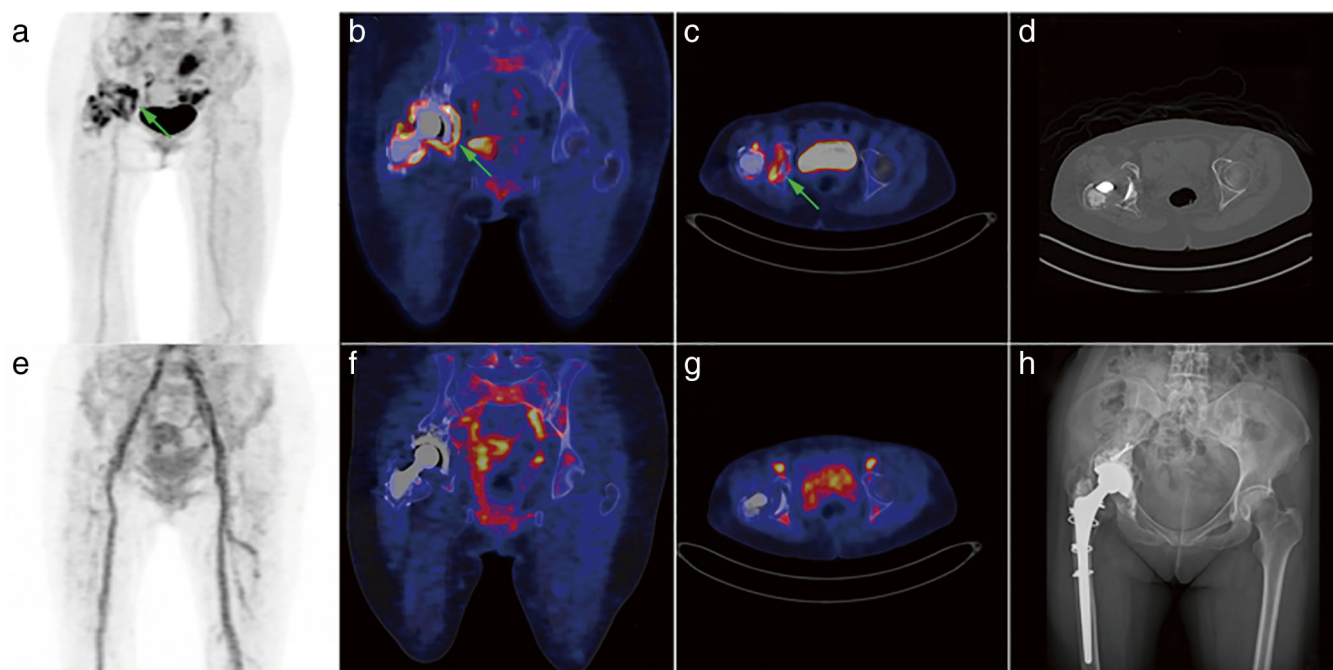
Imaging findings of [^{18}F]FDG PET/CT and [^{68}Ga]citrate PET/CT in a patient with a history of right total hip arthroplasty performed 16 years prior to imaging. [^{18}F]FDG PET/CT showed increased uptake around the prosthesis (a–d, green arrows), while [^{68}Ga]citrate PET/CT had no obvious tracer uptake (e–g). Cup loosening with synovial hypertrophy and clear joint fluid were observed during surgery. This confirmed [^{18}F]FDG PET/CT false positives. Adapted from Tseng *et al.* [34] (this article is distributed under the terms of the creative commons attribution 4.0 international license: <http://creativecommons.org/licenses/by/4.0/>).
